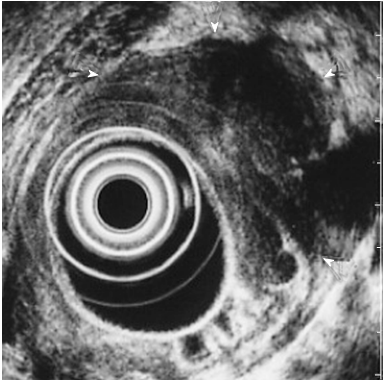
Endoscopic ultrasonographic image after inflammation. On endoscopic ultrasonography (EUS), the lesion was more swollen, with a diameter of 35 mm. The internal echo-pattern was more hypoechoic than in the previous EUS (arrow heads).
